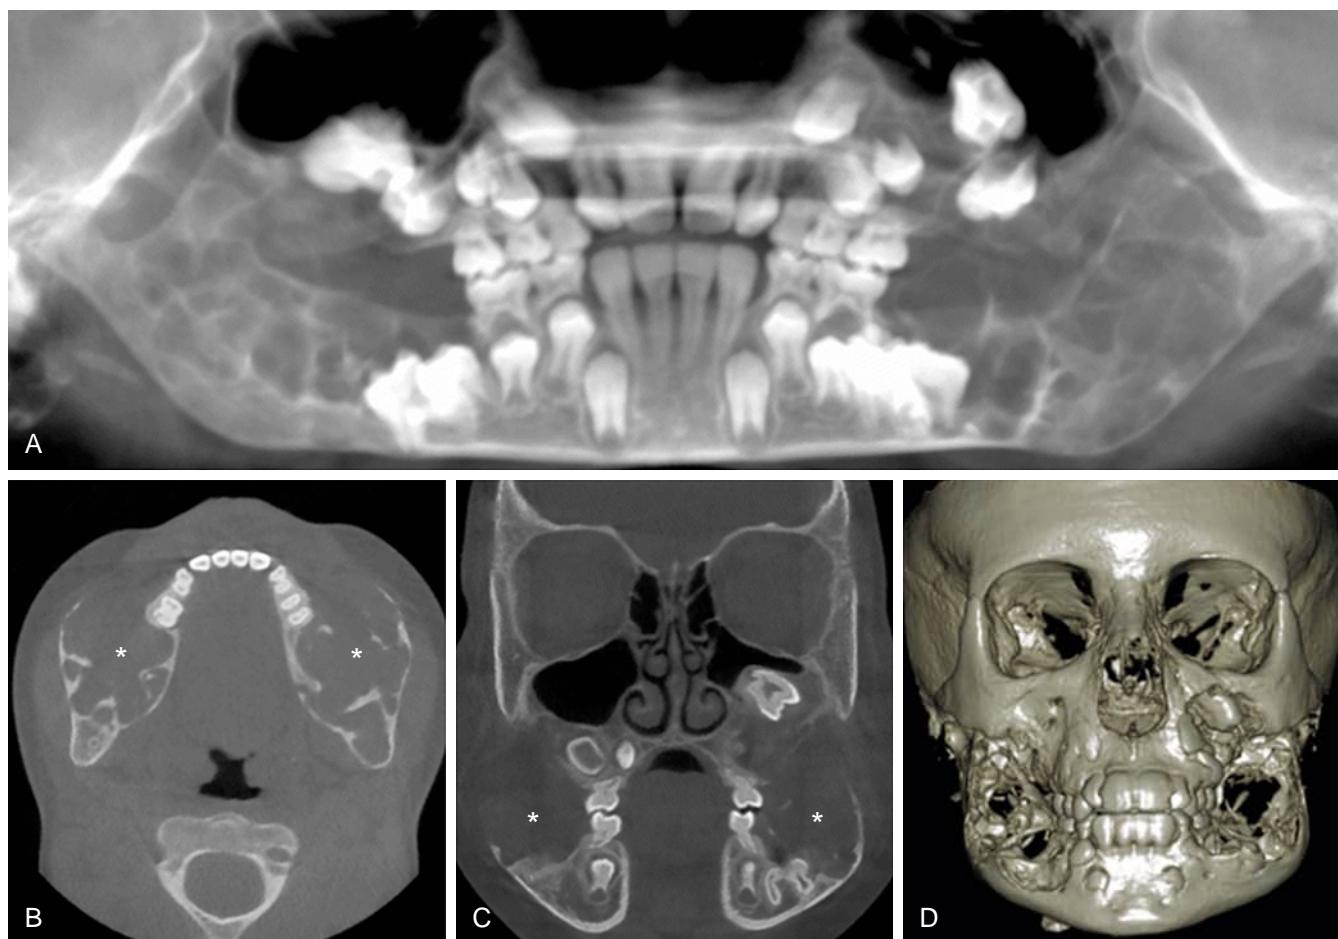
An 8-year-old boy with progressive painless and symmetric bilateral facial enlargement. (A) Translucent cone beam computed tomography (CBCT) thick-slab reconstruction shows well-defined bilateral multilocular radiolucencies with deformation and symmetric bilateral enlargement of the mandible and maxilla, and dental abnormalities (displaced permanent teeth and unerupted first molars). (B) Axial and (C) coronal CBCT images show multilocular pseudocystic osteolytic lesions with a few irregular bony septa (asterisks), no periosteal reaction, teeth displacement, and inferior alveolar nerve canal invasion. (D) Hypertrrophic osteolytic mandibular and maxillary lesions typical of cherub face as seen on the three-dimensional CBCT reconstruction. (Reproduced from the original with permission from *Insights Imaging*, Volume 9, pages 571–589, by Salvatore Stefanelli, Pravin Mundada, et al., "Masses of developmental and genetic origin affecting the paediatric craniofacial skeleton," (Copyright 2018), Springer Nature Publisher, (<http://creativecommons.org/licenses/by/4.0/>)
